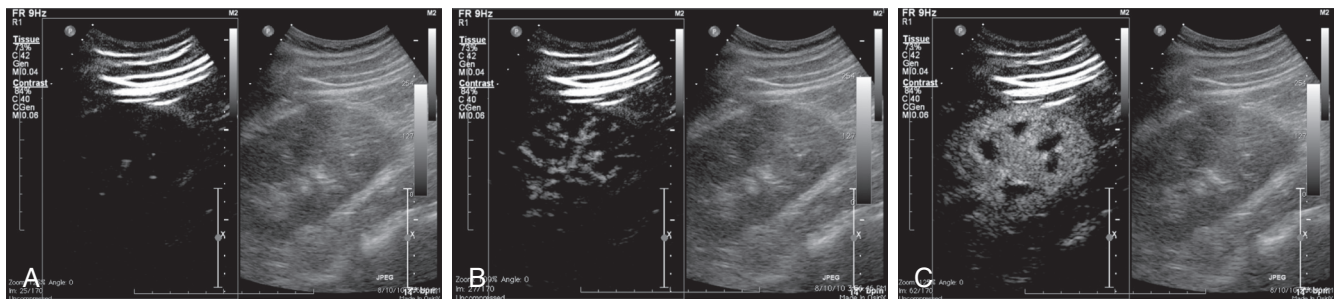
Example of destruction-refilling sequences obtained in a 60-year-old male patient, 1 hour after coronary artery bypass surgery. Each part of the figure is divided in two; the left parts show contrast-specific images and the right parts show standard B mode images. After the destruction flash (4a left), no signal is detectable in the contrast specific image (i.e., all the microbubbles have been destroyed). Five seconds after destruction (4b left), partial replenishment of the main arteries with contrast can be noticed. Ten seconds after destruction, the kidney is replenished fully with contrast (4c left). No significant changes are observed in B-mode images (4a-c right). (Modified from Schneider A, Johnson L, Goodwin M, Schelleman A, Bellomo R. Bench-to-bedside review: Contrast enhanced ultrasonography—a promising technique to assess renal perfusion in the ICU. *Crit Care*. 2011;15[3]:157.)
